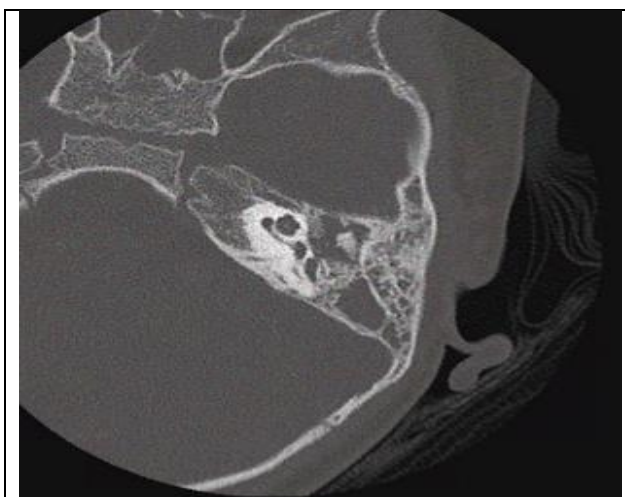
Temporal bone CT at diagnosis
